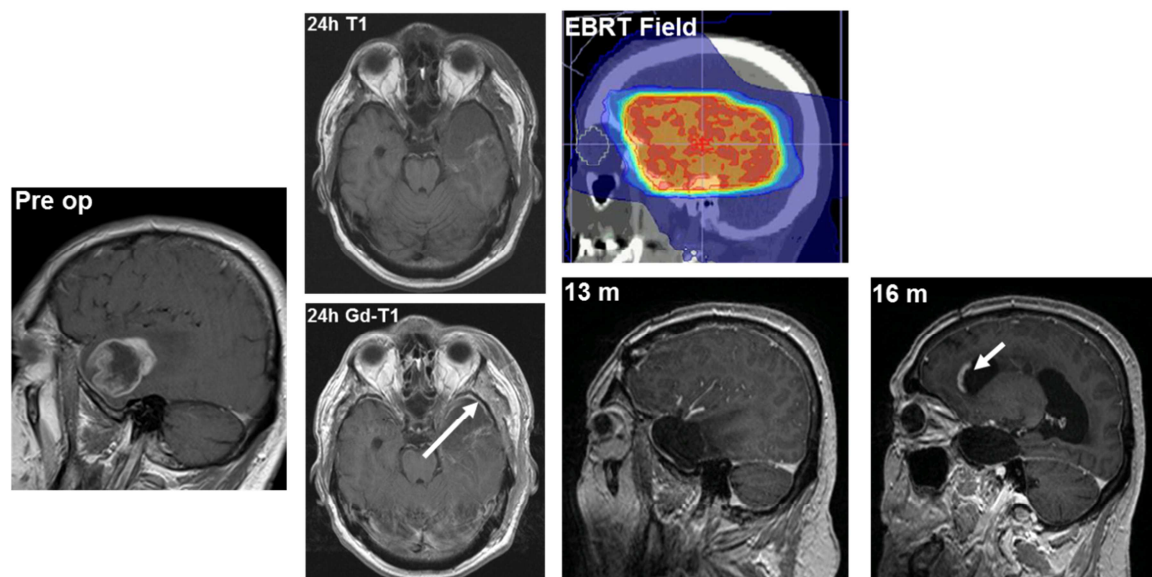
T1-weighted imaging studies of a patient with distant recurrence. Shown are images of a 60 year old male patient with a left temporal GBM (unmethylated MGMT promoter). Recurrence occurred in-field with regard to EBRT and out-of-field with regard to IORT (20 Gy surface dose).
